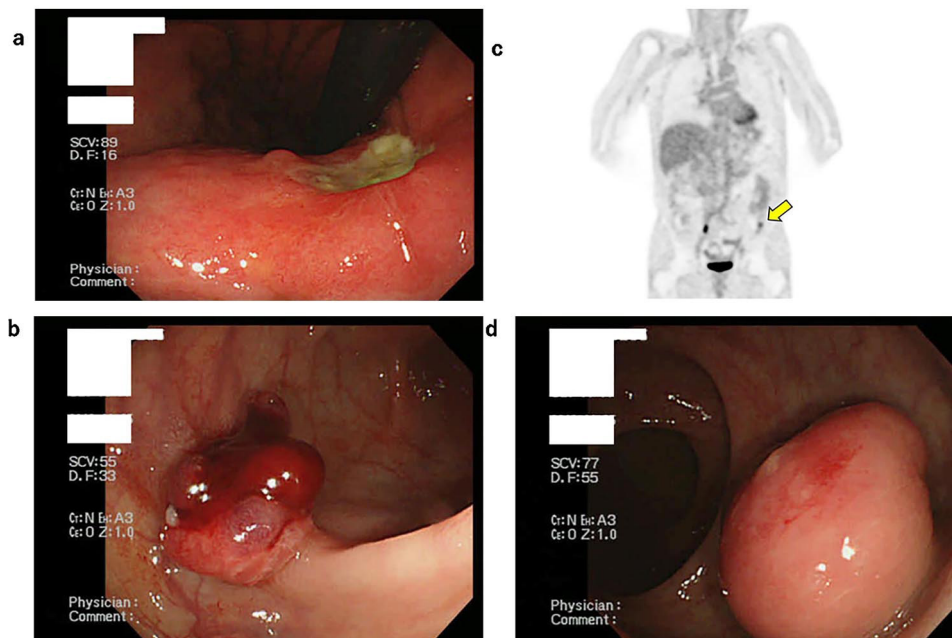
Examination of gastrointestinal tract. Upper gastrointestinal endoscopy shows an ulcer at the gastric angle in the lesser curvature of the stomach (a). PET-CT shows a hot spot in the sigmoid colon (b). Colonoscopy shows a 15-mm protruding lesion in the sigmoid colon, and a submucosal lesion is also seen in the lower rectum (c,d).
